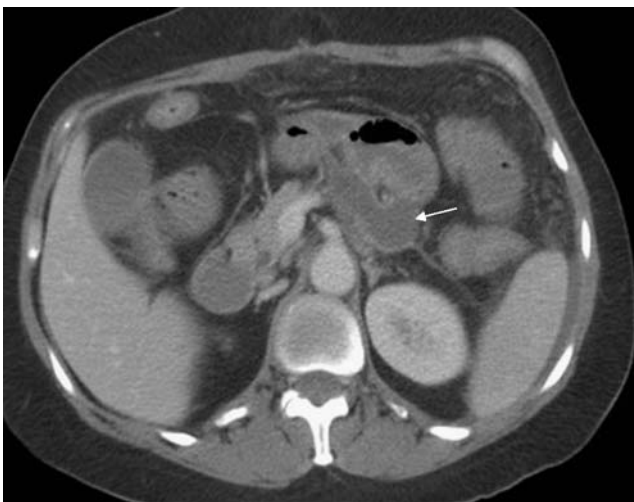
CT images from case 2: Contrast-enhanced CT scan reveals an irregularly shaped, rim-enhancing cystic structure (*arrow*) beneath the body and tail of the pancreas.
